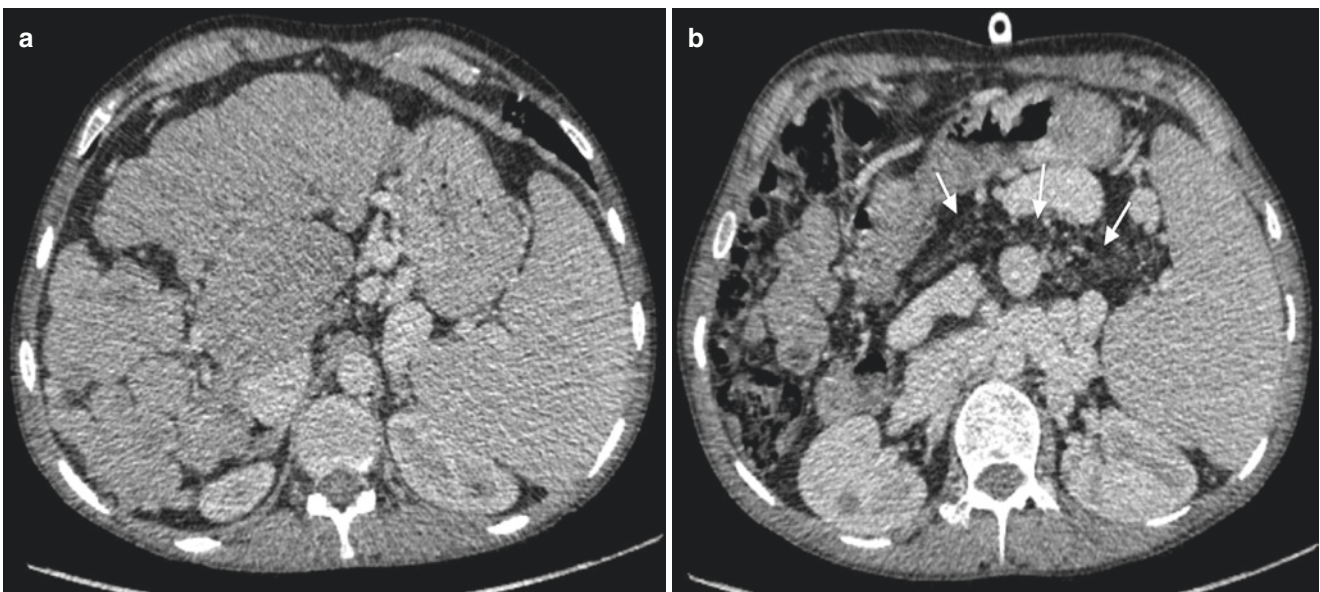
CT of a patient with cystic fibrosis and chronic liver disease. (a) Nodular cirrhotic liver and signs of portal hypertension, splenomegaly and varices. (b) Fatty infiltration of the pancreas (arrows)
